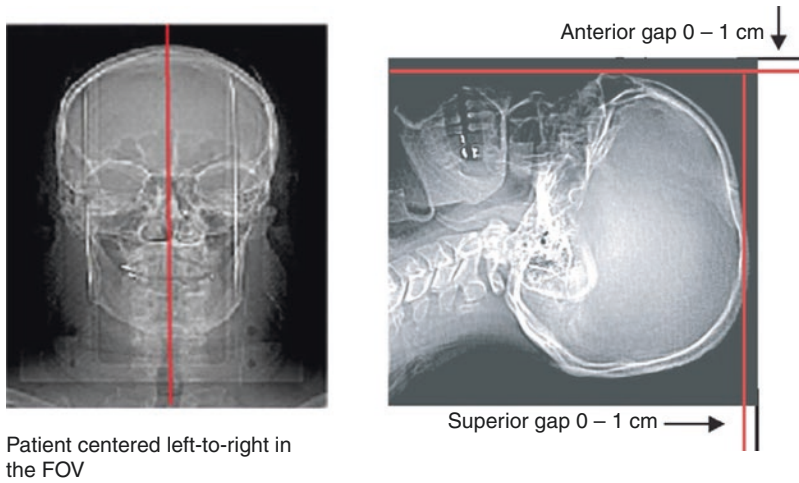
Field of View (FoV) adjustment in CT imaging for cranial applications. The patient is centered laterally within the FoV, as shown on the left panel. The FoV should extend by 1 cm from the anterior and superior tips of the patient, as shown on the right panel. (Image taken
